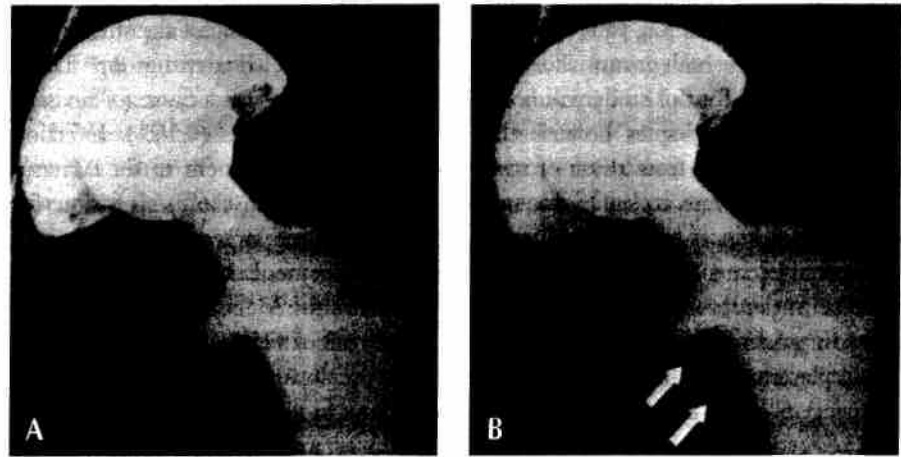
Radiographs demonstrating 1 of 96 hips (1%) that had a radiolucency 1 × 1 mm in size, beneath the collar, at 1-year follow-up. This radiolucency increased to 10 × 20 mm in size at 5-year follow-up (arrows). A, Postoperative radiograph. B, Radiograph obtained at 5-year follow-up.
